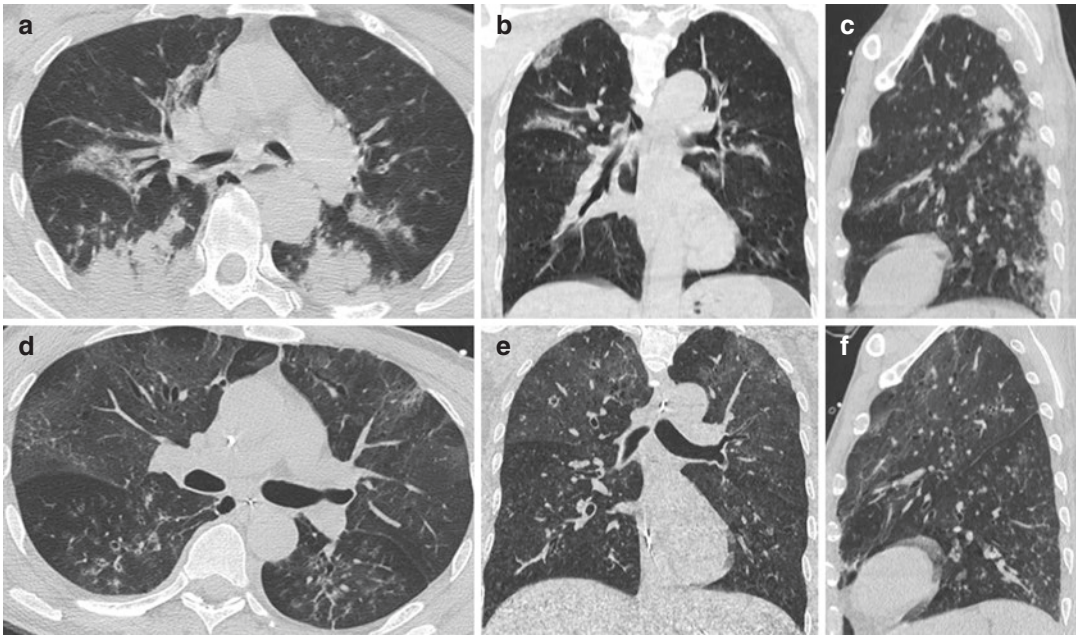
Complication of a pulmonary contusion. (a–c) Post-traumatic CT-scans show bilateral areas of contusion. Although the relative clarification of contusion areas in the posterior regions, we can appreciate the emerging
